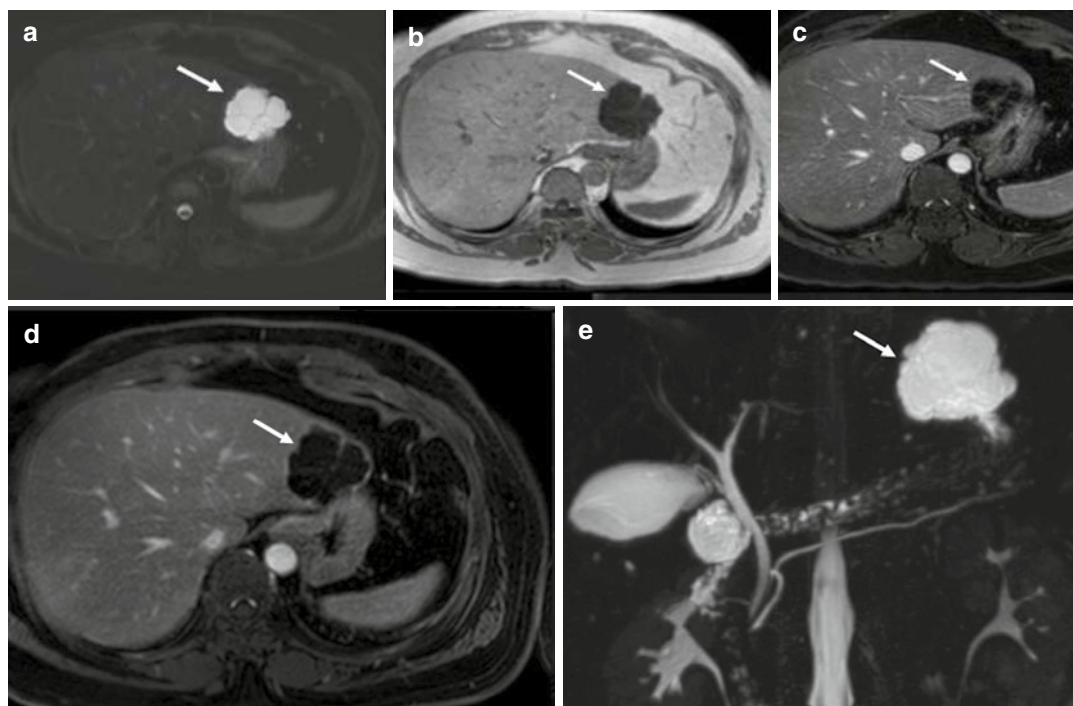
A 50-year-old female with hepatic mucinous cystic neoplasm (biliary cystadenoma). (a, b) Axial T2-weighted MRI (a) showed a well-defined lobulated hyperintense lesion in the liver (arrow), appearing hypointense on T1-weighted MRI (b), with multiple
